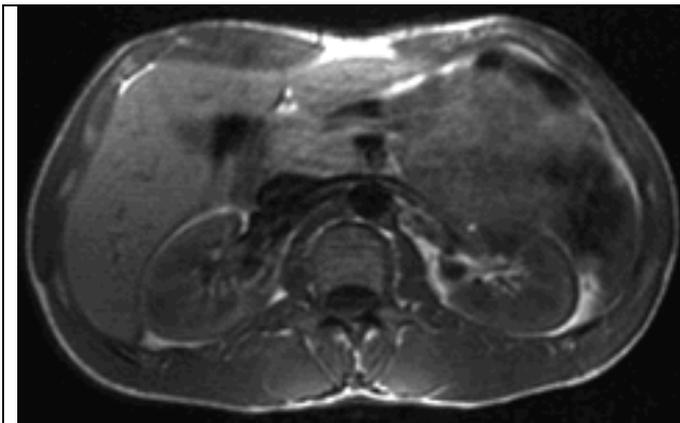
MRI of the abdominal cavity at the level L2. Axial T1-WI normal kidneys.
